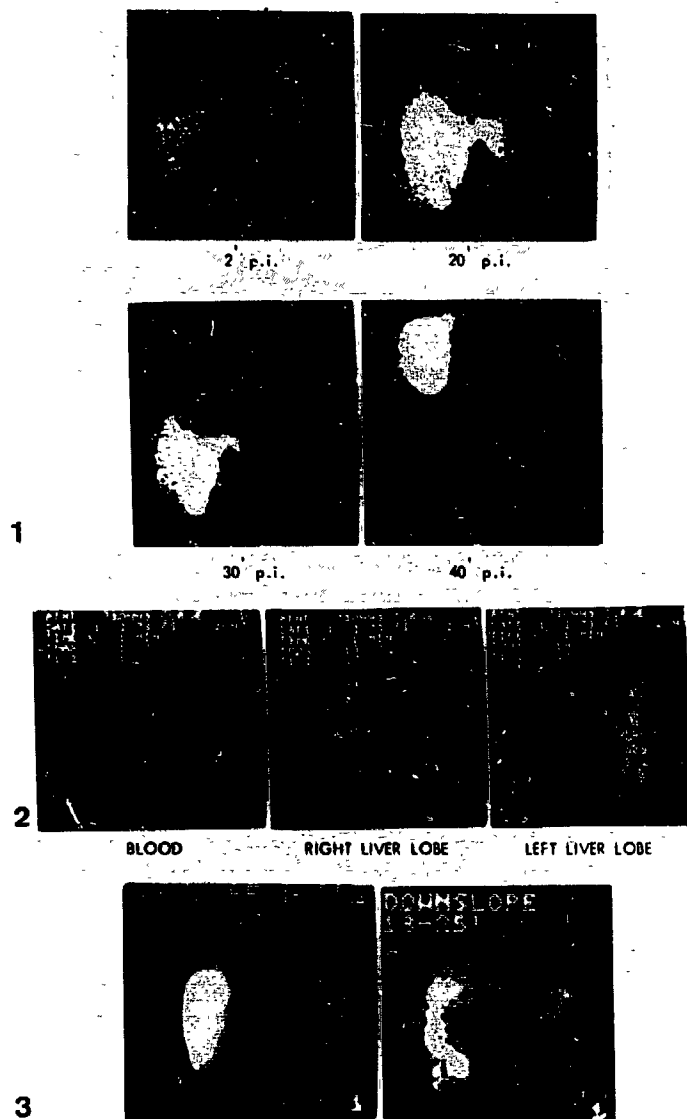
1-3 Cholescintigraphy in a patient with alcoholic hepatitis and steatosis.
